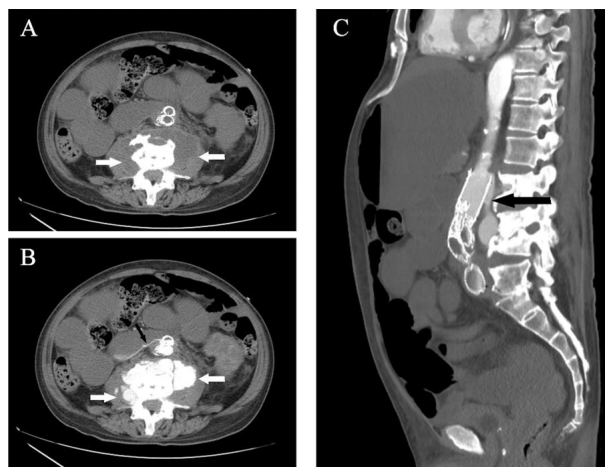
A, Non-contrast axial CT. Low-attenuation fluid-density collections are in the bilateral psoas/paravertebral compartment (white arrows). Note the "Red Flag" sign: The loss of the fat plane between the abscess and the aortic stent graft, which necessitates further vascular evaluation. B, Arterial-phase axial CTA. IV-iodinated contrast opacifies the bilateral psoas abscess cavities (white arrows), confirming the "Red Flag" of active fistula communication. Besides, an aorto-enteric fistula is revealed (black arrow). C, Sagittal view of arterial-phase CTA. Type Ia endoleak at the edge of the aortic graft with fistula connection to the left psoas abscess cavity (black arrow).
